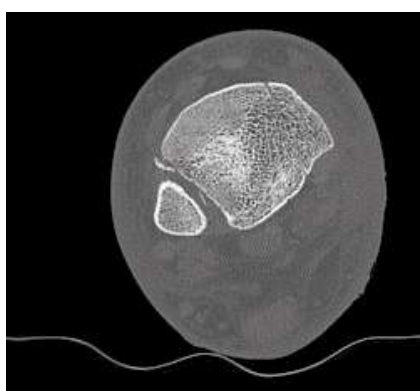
CT examination in axial and coronal cut.
